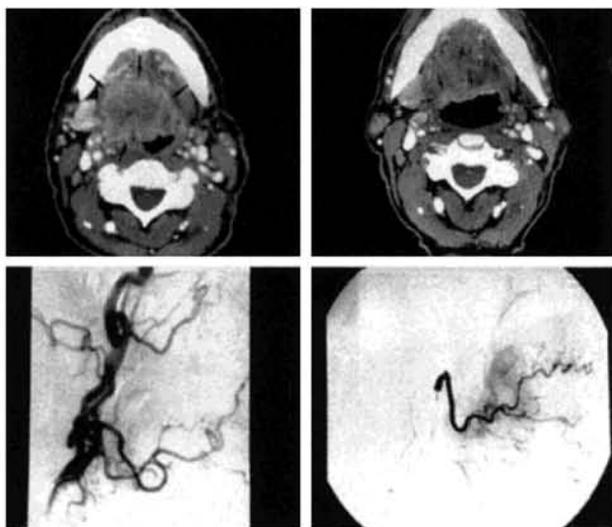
Carcinoma of the tongue. Computed tomography with contrast medium (top left); the arrows indicate the tumor margins. Result after three cycles of intraarterial chemotherapy (top right). Angiogram of right common carotid artery (bottom left). Catheterization and angiography of lingual artery (bottom right).
